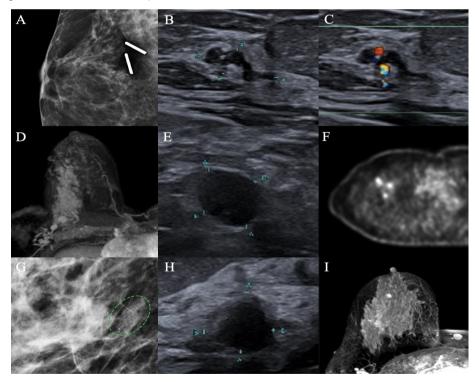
Types of recurrence (A-C) Local recurrence in a 55-year-old woman with a history of IDC. Indistinct density and accompanying microcalcifications in the operation site on the right MLO view and a non-mass hypoechoic area associated microcalcifications on US diagnosed as IDC (D-F) Regional recurrence in a 53-year-old woman with a history of grade 3 DCIS with microinvasive carcinoma. Preoperative MRI demonstrating extensive non-mass enhancement of DCIS, US shows ALN metastasis with the absence of hilar echogenicity (G-I) Secondary primary in a 50-year-old with a history of grade 2 IDC. MG shows a cluster of pleomorphic microcalcifications, while US and MRI demonstrate a mass appearance at the retro areolar area diagnosed as IDC
